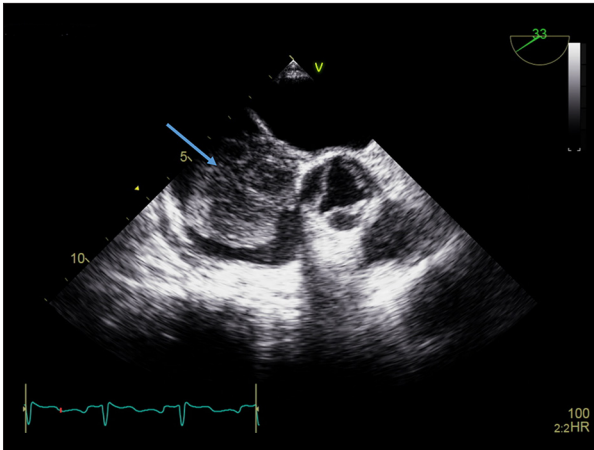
Transesophageal echogram (TEE) parasternal short view. There is a right atrial mass (arrow) with partial obstruction of the tricuspid valve with involvement of the aortic annulus. The mass is described as slightly lobulated and rounded, attached to the posterior wall of the right atrial and slightly to the septum with a wide base. The tumor is almost filling the whole right atrial cavity.
